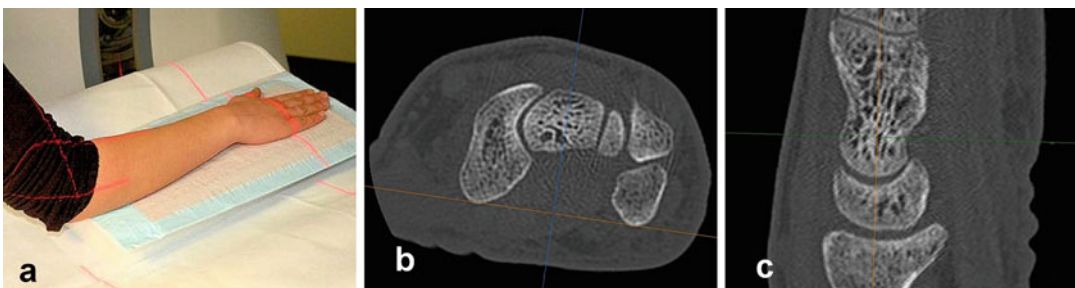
Acquisition technique of carpal computed tomography (CT). (a) Positioning for transaxial CT imaging. The patient is standing beside the CT gantry, and the pronated forearm and hand are placed flat and in longitudinal direction on the gantry table. (b) Planning of coronal and sagittal MPR (multiplanar reconstruction) on this
